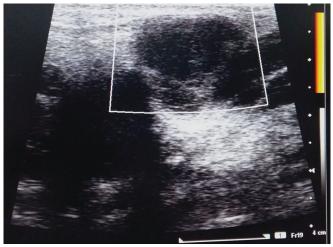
Gray scale ultrasonography showing multiple enlarged and heterogeneous lymph nodes with loss of nodal architecture
